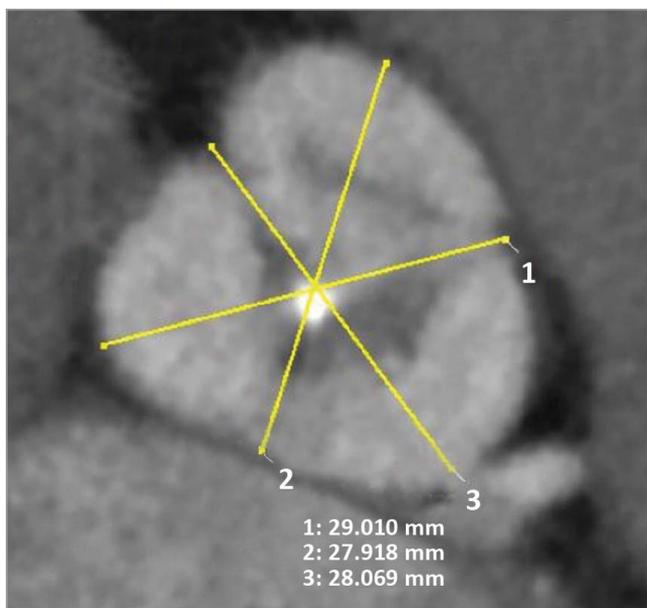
Computed tomography of the aortic valve showing very minimal aortic valve calcification.
